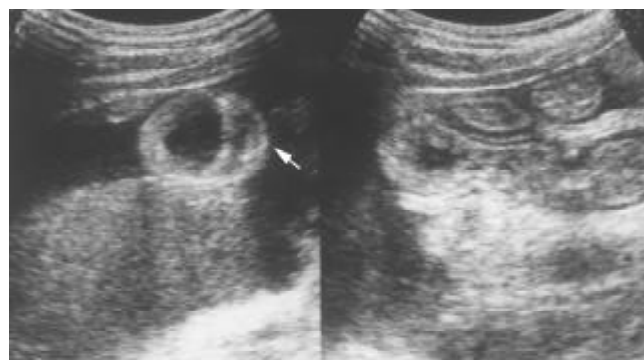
Transverse sonography of the proximal small bowel in the right subcostal area showing general thickening of the wall (white arrow) and ascites.
